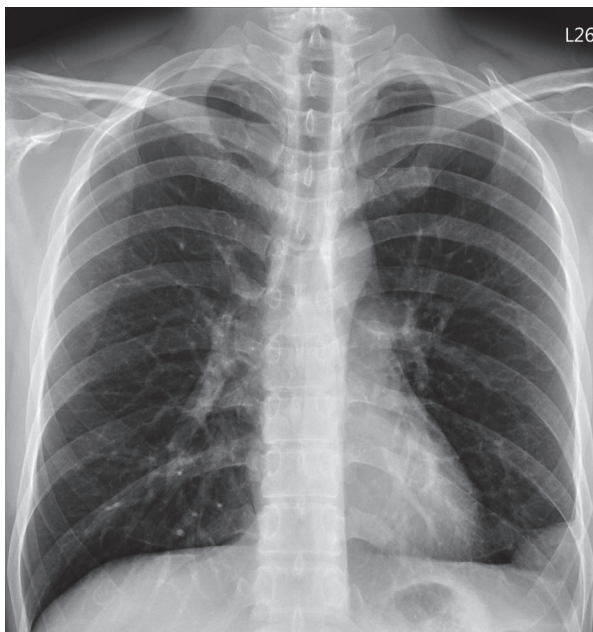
Chest X-ray showed a mass lesion at the left costophrenic angle.
